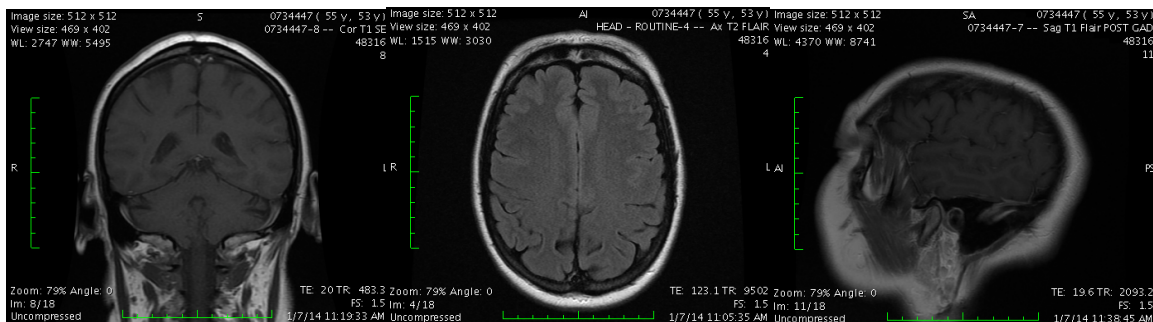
MRI of the head - no lesion at right parietal region - January 2014
